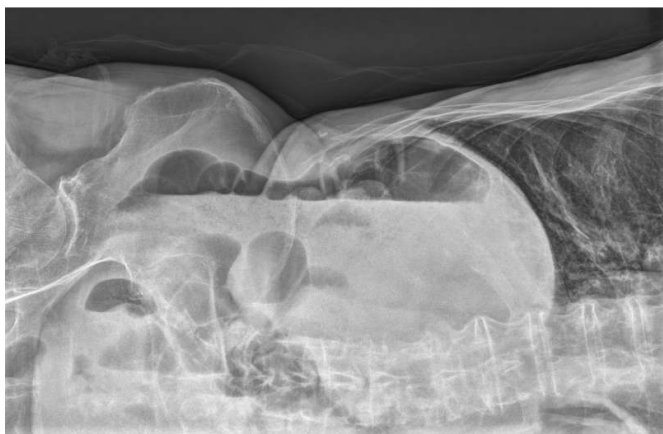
Abdominal x-ray showing signs of small intestinal obstruction
